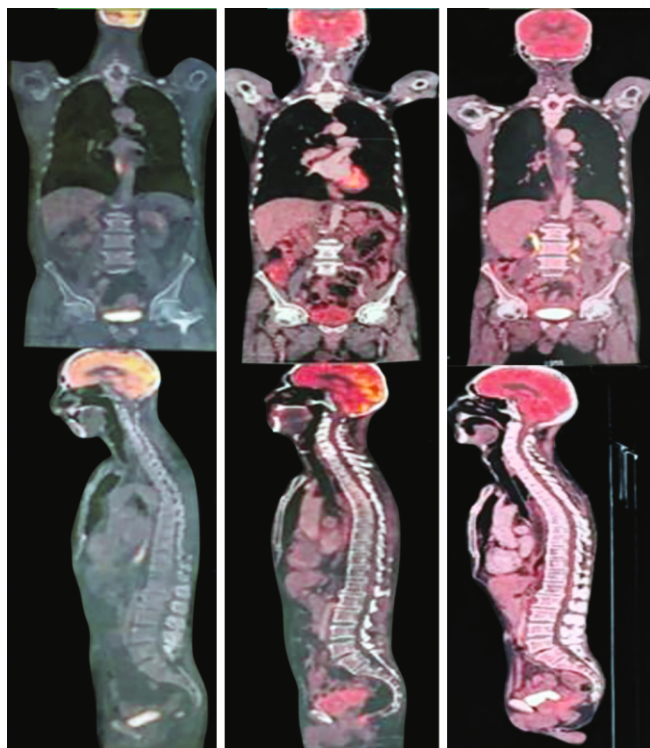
Serial PET/CT imaging before treatment, post-treatment response, and recurrence.
